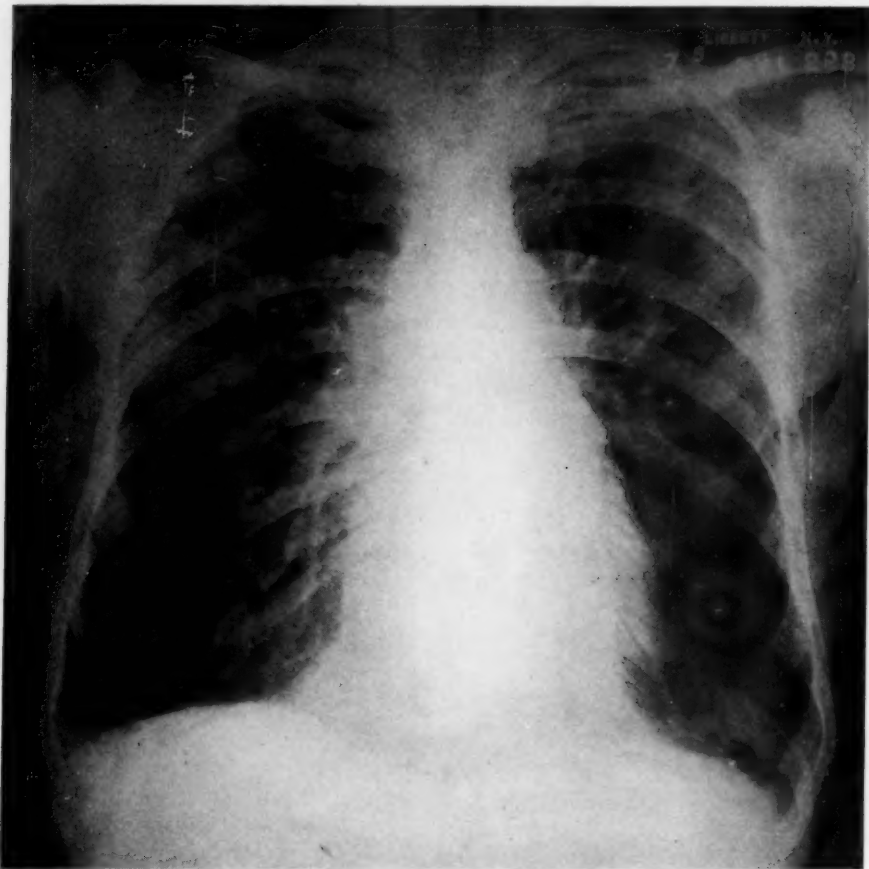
(Case 1.) Roentgenogram taken July 5, 1939. Complete clearing of the right lung field; slight infiltration left upper lobe. The cardiac silhouette remains enlarged with straightening of the left border.
